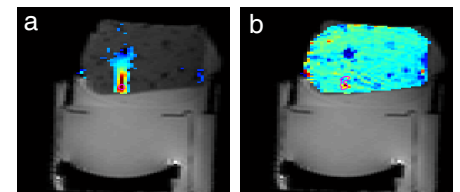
Ultrasound heating of ex-vivo tissues, (a) shown with temperature overlay and (b) with T<sub>2</sub> overlay.
